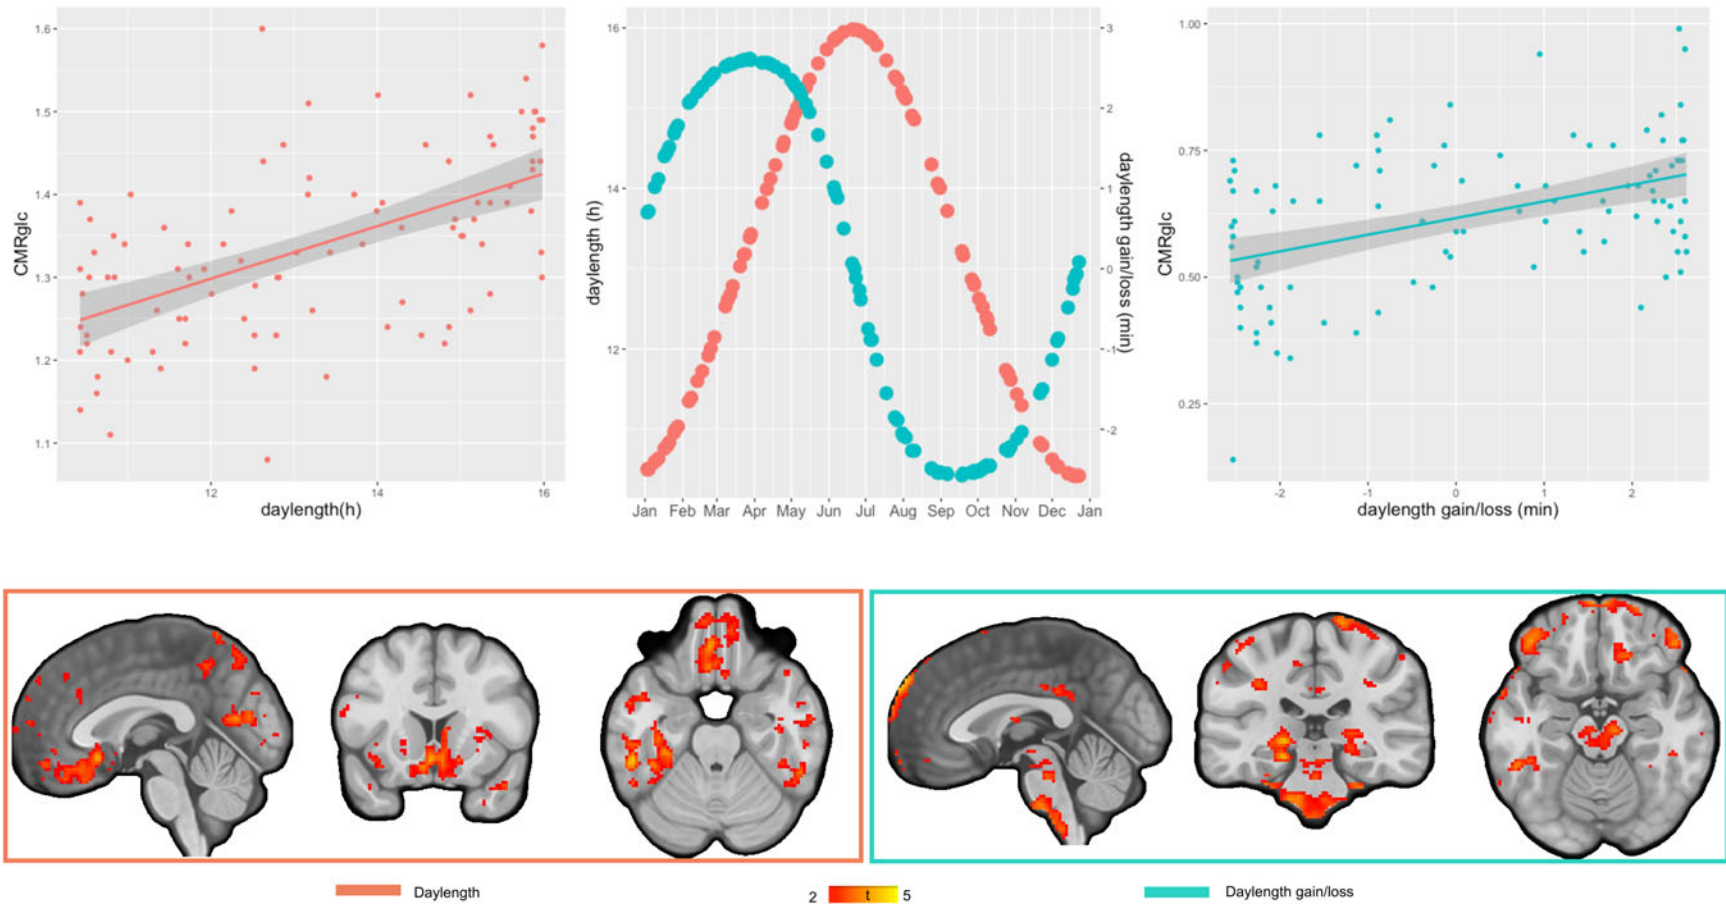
Seasonal effects on rCMRglc. Middle: Daylength (red) and day-to-day changes in daylength (blue) when the FDG-PET scan were obtained for the 97 participants. Left: Effects of daylength on rCMRglc. (Upper) Linear plot of daylength with rCMRglc values extracted from significant clusters. (Bottom) t-map of the association of rCMRglc with daylength. Right: Effects of day-to-day changes in daylength on rCMRglc. (Upper) Linear plot of day-to-day changes in daylength with rCMRglc values extracted from significant clusters. (Bottom) t-map of the association of rCMRglc with day-to-day changes in daylength.
